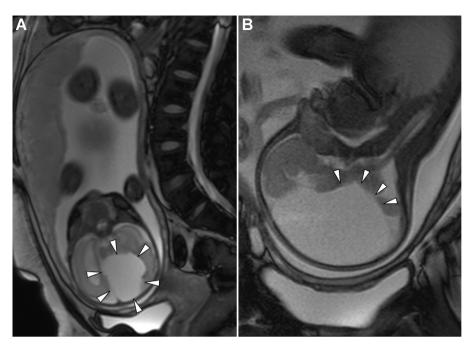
Results of T2-weighted MR images at 30 weeks of pregnancy. (A) Fetus MRI showing a cystic lesion in the interhemispheric region (arrows). (B) A sagittal image showing the absence of corpus callosum (arrows).
